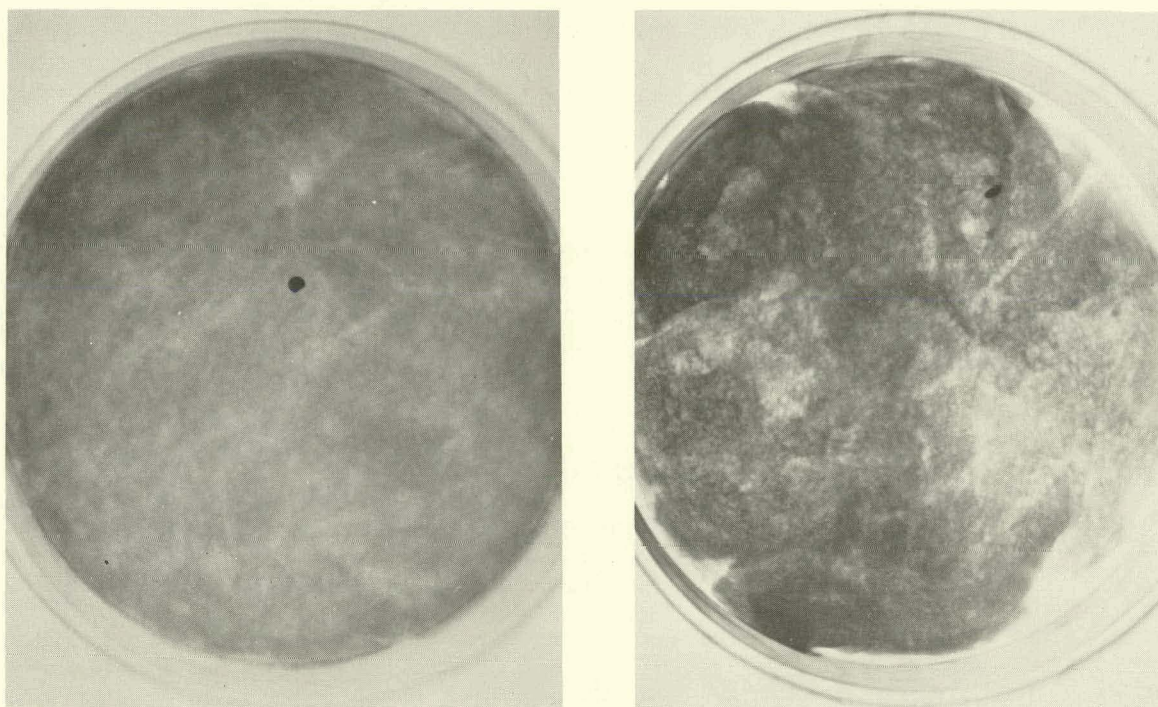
Prints made from radiographs of fecal samples (in plastic bags inside waxed cardboard cartons) voided 16 days (left) and 24 days after the incident. The silver disks are easily seen. (ANL neg. 235-76-21)
